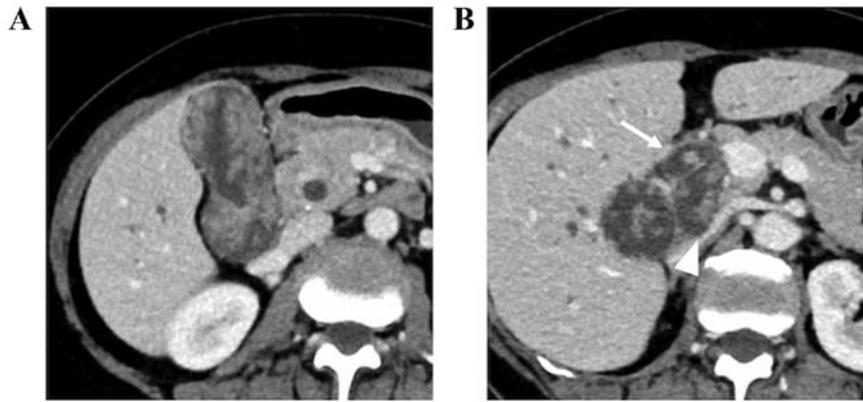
Findings of contrast-enhanced CT. (A) Contrast-enhanced CT revealed that the gallbladder was almost completely filled with papillary lesions. (B) The tumor extended to the common bile duct (arrow) through the cystic duct (arrow head). CT, computed tomography.
